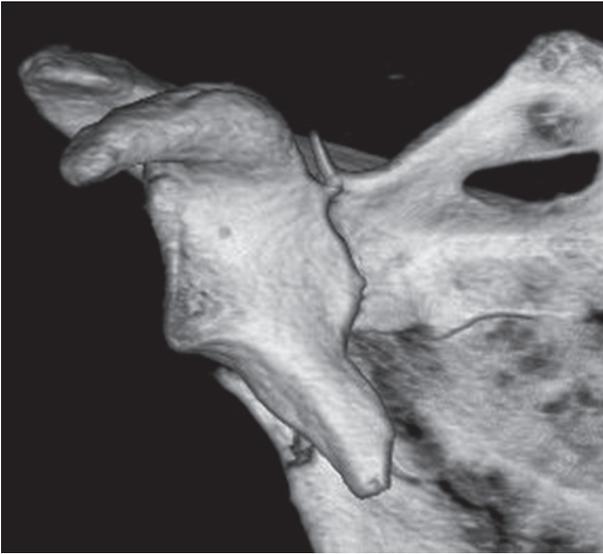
Fracture of the scapular (surgical) neck (fissure of the scapular body also visible), 3D CT reconstruction, anterior view
